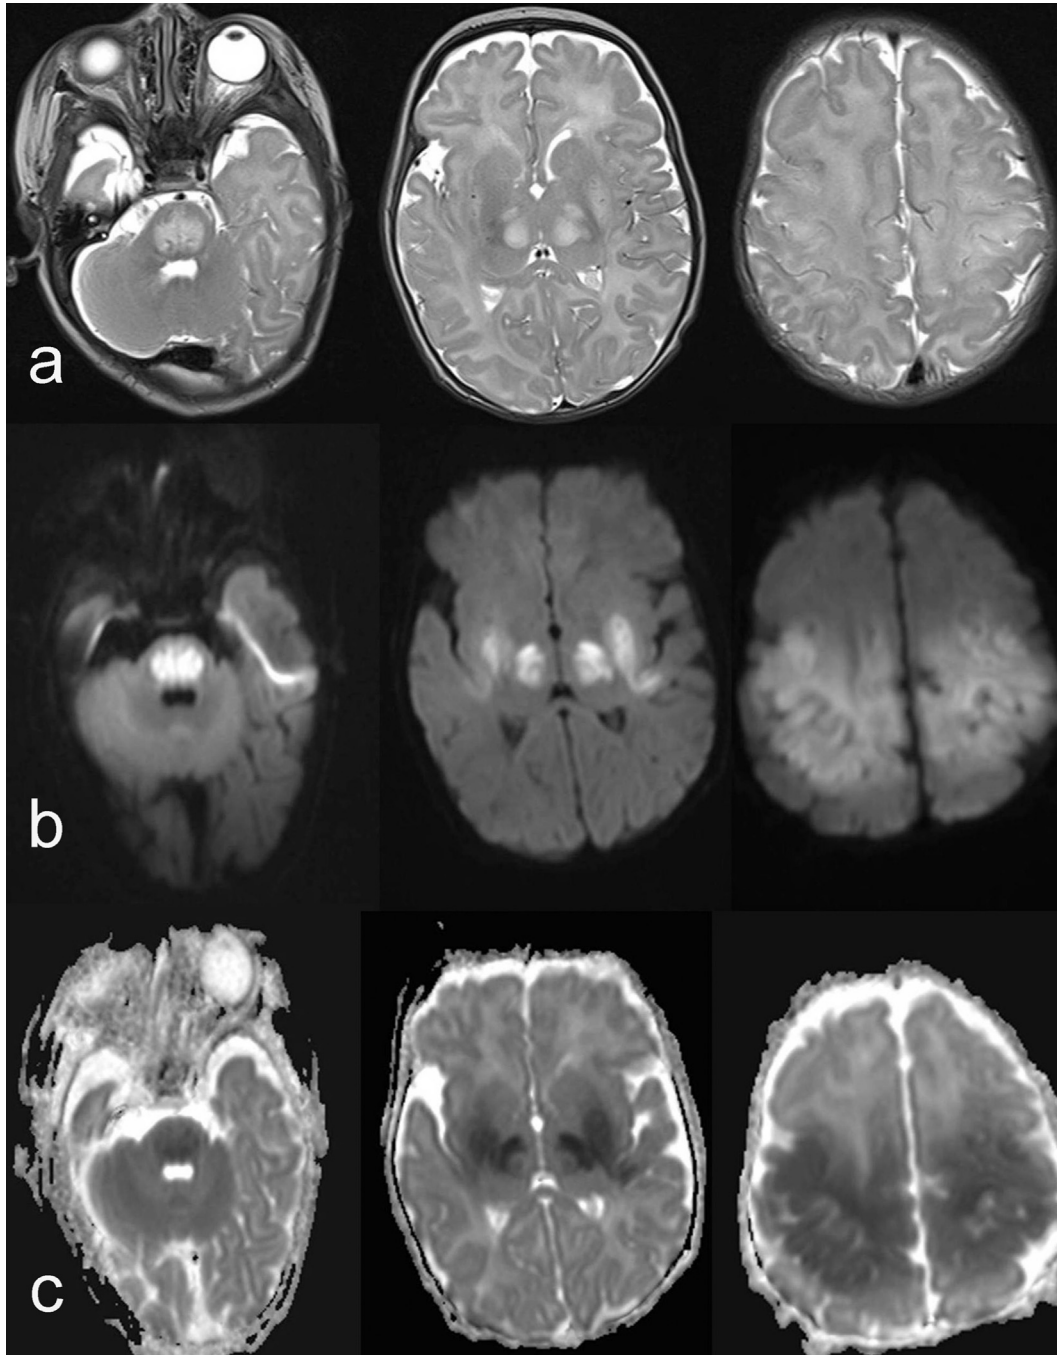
Axial T2-weighted MR images (a) show increased signal intensity in pons, medial thalami, putamina, frontal and, parietal lobes. There is restricted diffusion on DWI (b) and ADC map (c).
